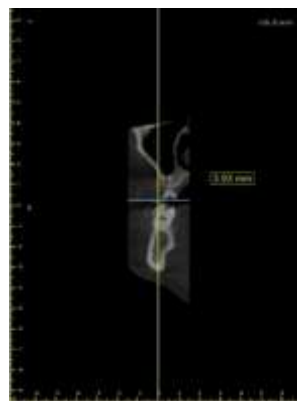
coronal cut of pre-operative CBCT shows 1mm remaining bone height.
